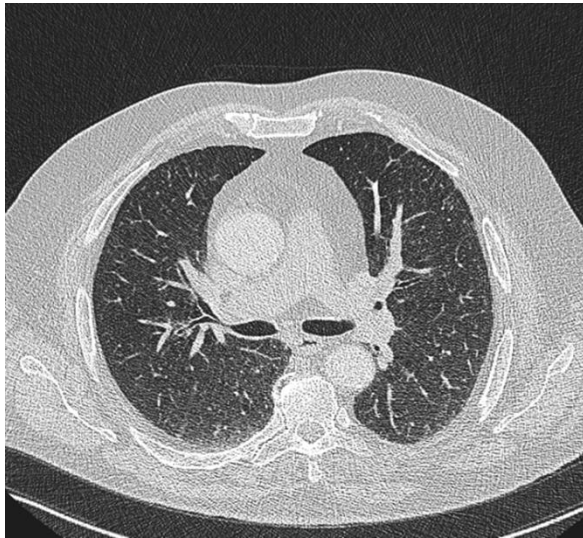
Post whole lung lavage CT scan- Reduced ground glass opacities.
